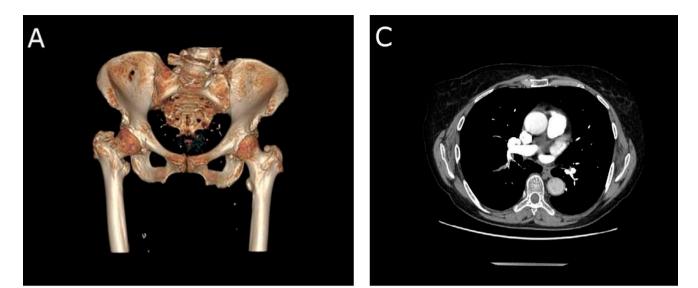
A-C. A 66-year-old patient with a fractured neck of right femur and pulmonary embolism. A – 3D view, B – pelvic X-ray, C – angio-CT image of pulmonary vessels
